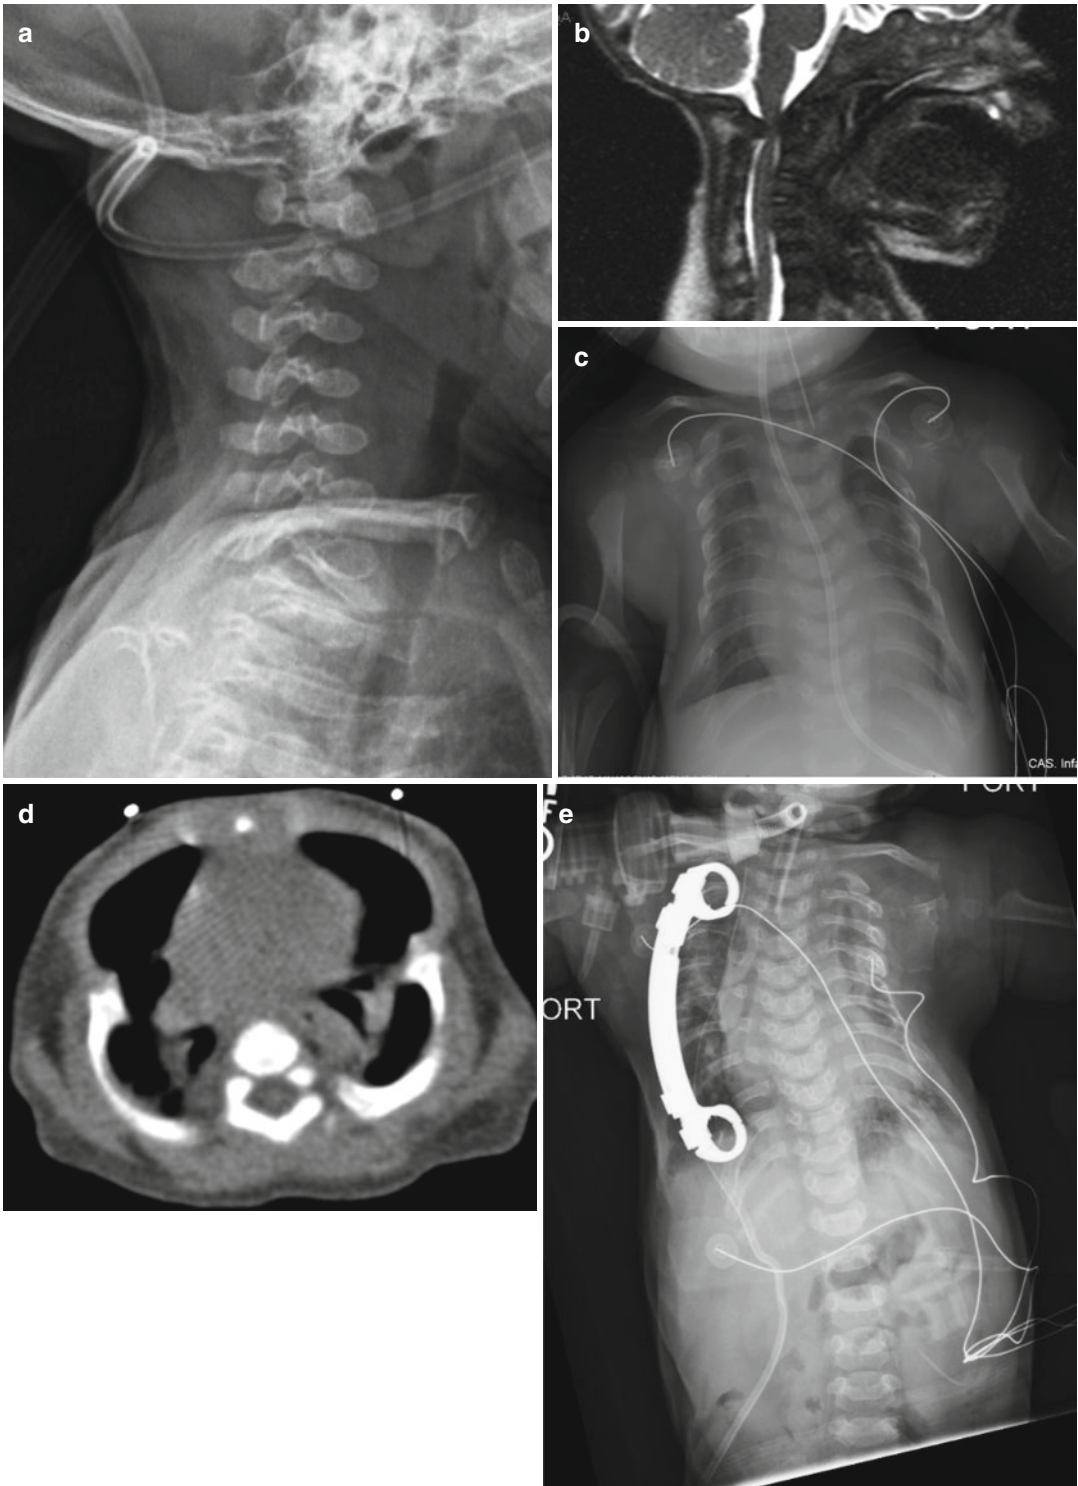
(a) C1 stenosis on lateral radiograph of a Jeune syndrome patient with intact neurologic evaluation. (b) Significant compression of spinal cord on MRI. The patient underwent surgical decompression. (c) AP radiograph showing a narrow “stove pipe” chest of Jeune
